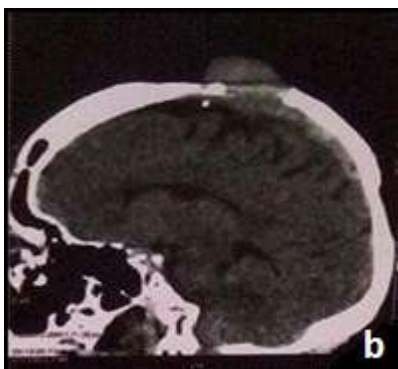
Brain CT scan: b: sagittale reconstruction showing an extra cranial process
